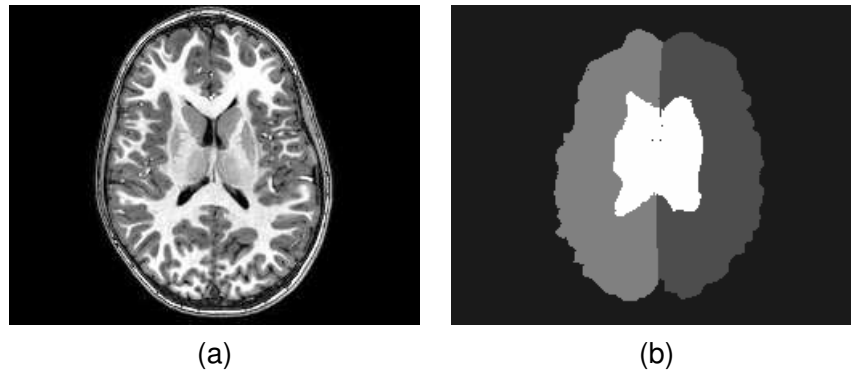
Results of applying the BrainSuite application to a MR brain scan. Shown is an example of the (a) original MR image and the (b) cerebral cortex mask of the MR image.
